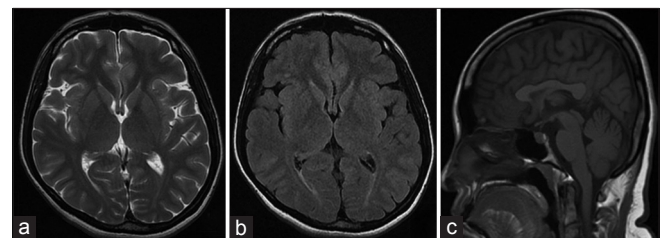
Twenty-four months later. (a) T2-weighted axial (b) axial fluid-attenuated inversion recovery and (c) T1-weighted sagittal magnetic resonance imaging show complete resolution of the cyst with no evidence of hemorrhage and normal-sized ventricles
